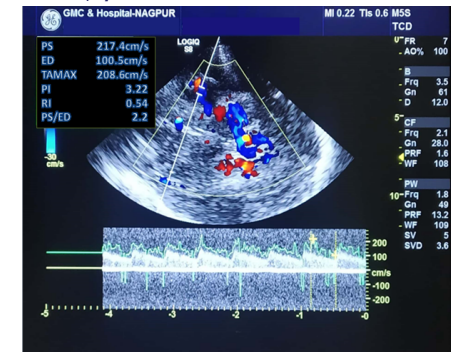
Shows Normal Waveform Of Mca In Colour Doppler Tcd Imaging.
